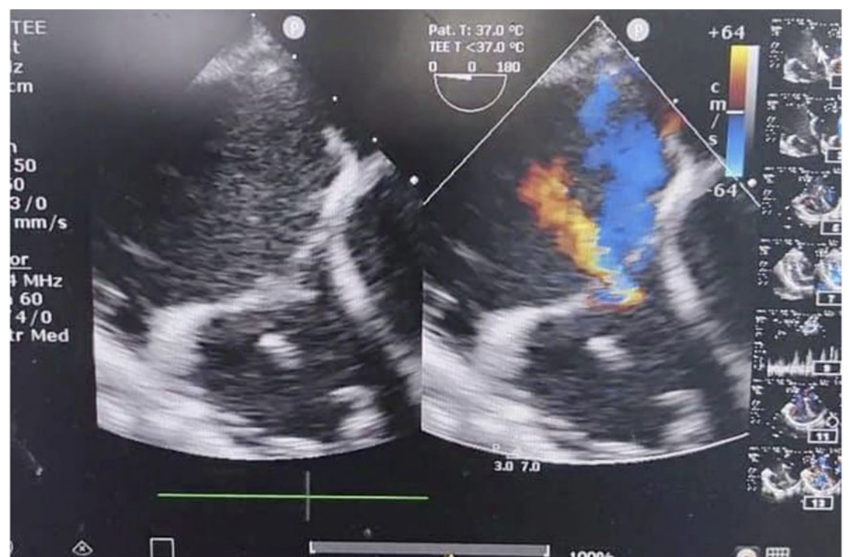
(b). Transoesophageal echo with mid oesophageal four chamber view showing moderate tricuspid regurgitation.
